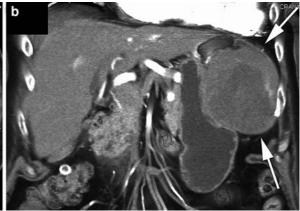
83-year-old woman with gastrointestinal stromal. Axial section (a) and coronal volume rendering (b) from IV contrast-enhanced CT show an 8.5 cm exophytic, necrotic mass arising
